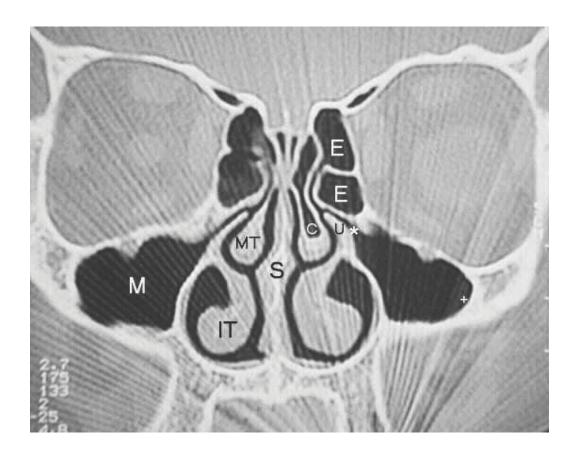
Normal anatomy of paranasal sinus as seen on CT scan
